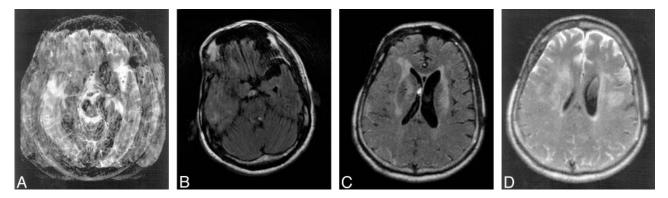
Images from a 53-year-old man with chronic hypertensive encephalopathy and acute mental status change. The patient was agitated and confused. Multisection T2-weighted FSE (repetition time [TR]/echo time [TE]_{eff} = 2800/120 ms) image (A) and standard single-shot, fast spin-echo, fluid-attenuated inversion recovery (SS-FSE-FLAIR) images at different levels (B-D). The T2-weighted FSE image is severely degraded by motion artifact. Images in B to D show no obvious motion artifact, though the patient moved during the acquisition of the images as shown by the change in angulation of the head between sections. In D, obvious high-signal-intensity areas are seen anteriorly in the subarachnoid space. More subtle changes are seen posteriorly. These mimic subarachnoid hemorrhage. A slight increase in gray-white matter contrast is seen in the frontal region in D, consistent with the brain in this region not having experienced the initial inversion pulse. The brain shows extensive white matter change.
